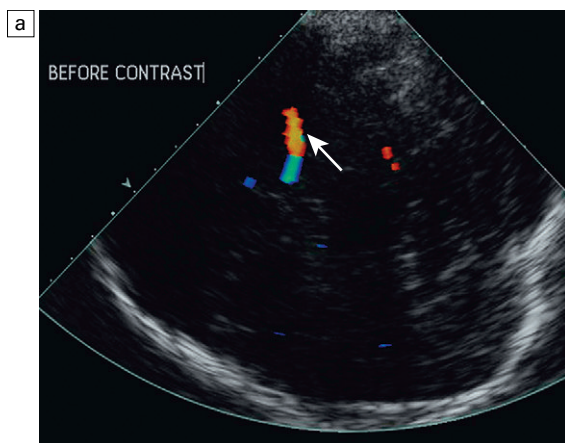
The application of microbubble contrast in transcranial ultrasound is useful; (a) on the baseline image a single vessel is visualised on colour Doppler ultrasound (arrow); (b) following the administration of Levovist® and using conventional colour Doppler ultrasound, both the circle of Willis and the draining veins of the brain are demonstrated (arrows).
